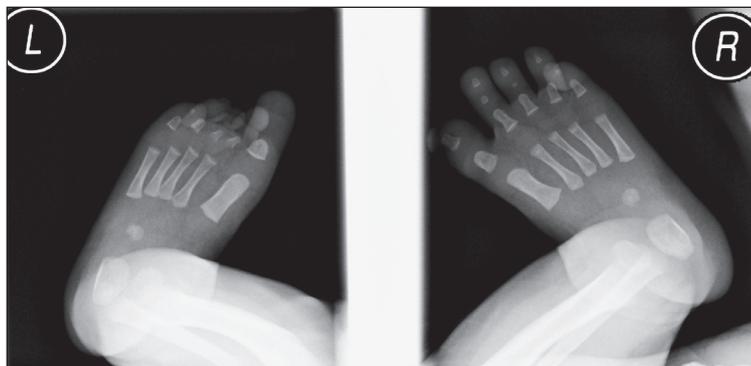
X-ray of both feet. Note the short toes on the left foot with absent phalanges in the second and third toes.
